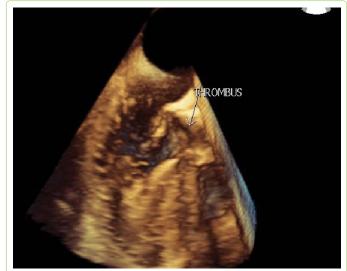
Echocardiography after discontinuation of Warfarin revealed TAVI thrombus (aortic side).
